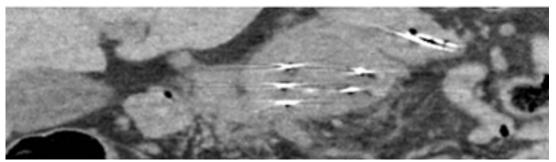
CT imaging without contrast medium was performed to evaluate needle positioning and check correct inter-probe distance.
